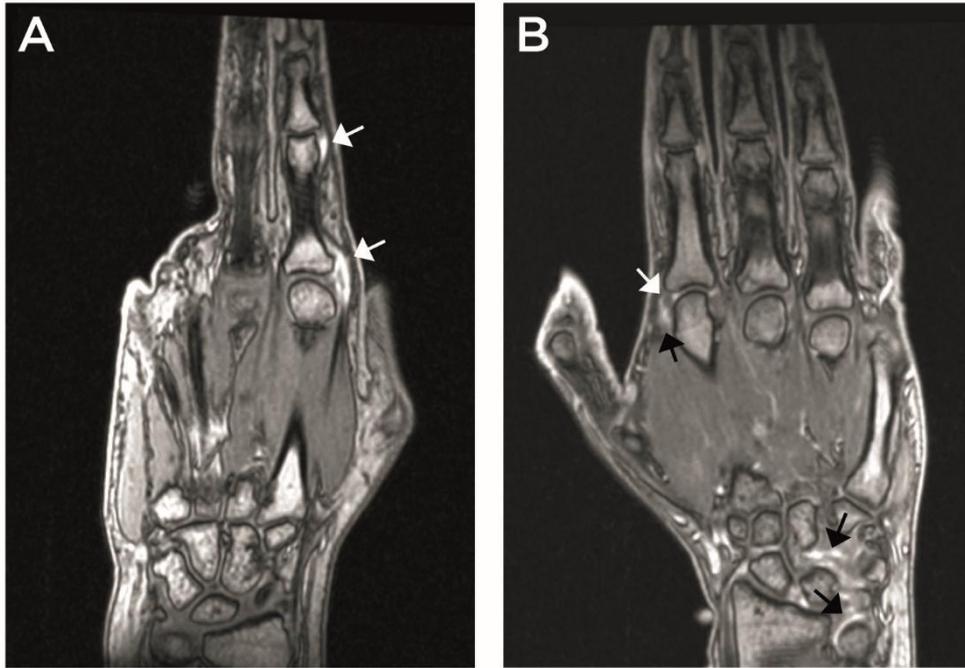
Baseline T1-weighted contrast-enhanced magnetic resonance imaging (MRI) scan of the hand/wrist joints of (A) an anti-citrullinated (ACPA)-positive arthralgia patient who developed arthritis in hand/wrist joints during 3-year followup. (B). an ACPA-positive arthralgia patient who did not develop arthritis in hand/wrist joints during 3-year followup. White arrows (panel A and B) and black arrows (panel B) indicate MRI signs of synovitis.
